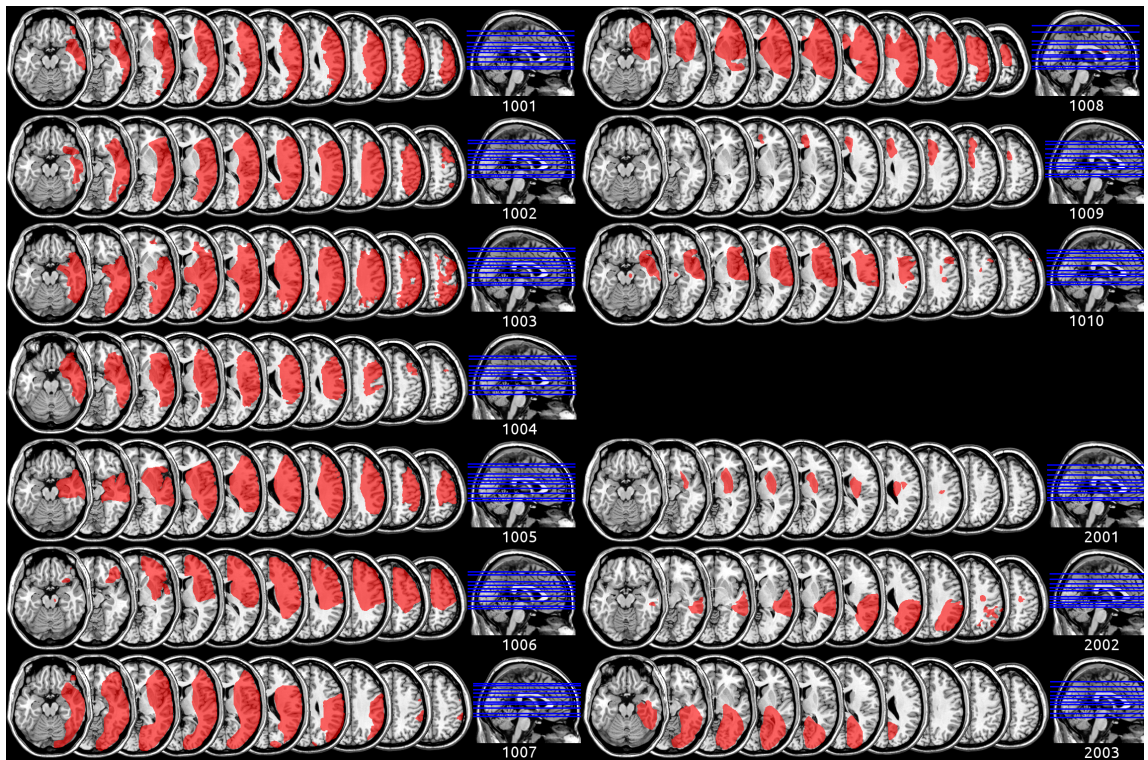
Hand-drawn lesions of patients in an structural MRI scan in standardised space. Patients 1001-1010 had frontal cortical involvement, patients 2001-2003 did not.
